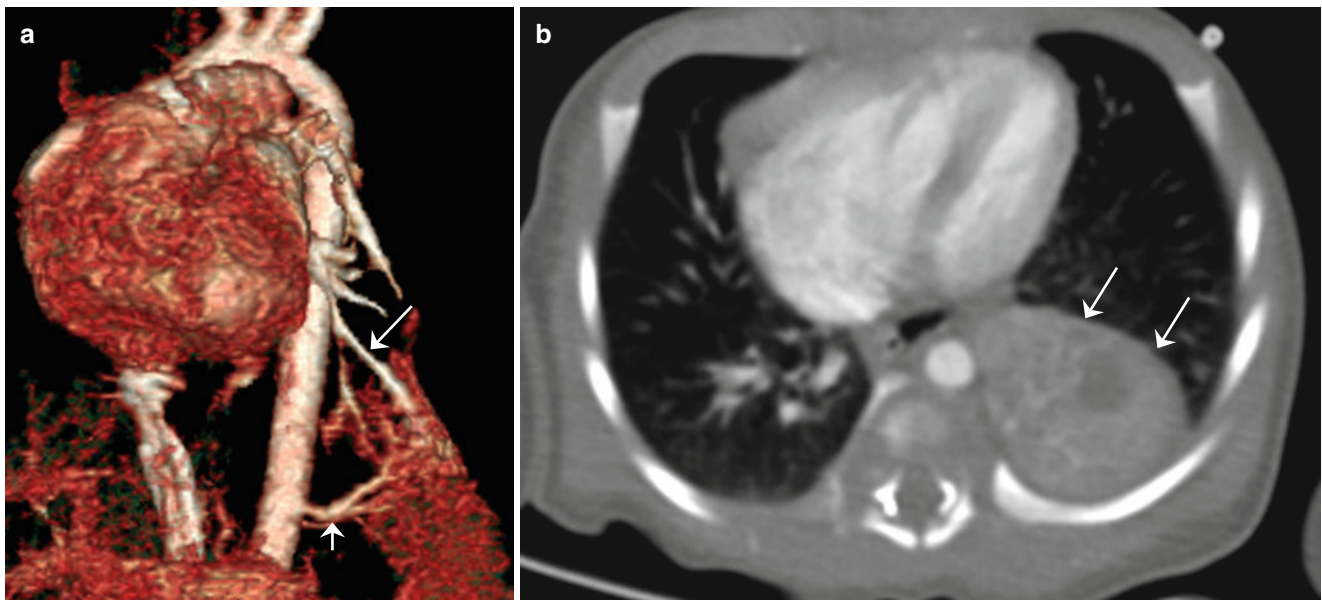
(a, b) Pulmonary sequestration. Volume-rendered CT image shows intralobar sequestration in the left lower lobe with its feeding artery (*short arrow*) arising from the descending aorta and a draining
